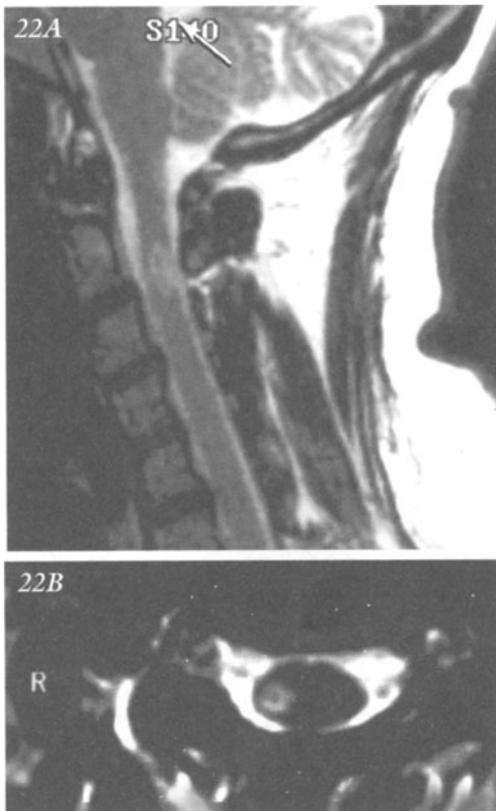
Multiple sclerosis involving the spinal cord. Case 9-12 see text. MRI A) Sagittal section. B) transverse section.
